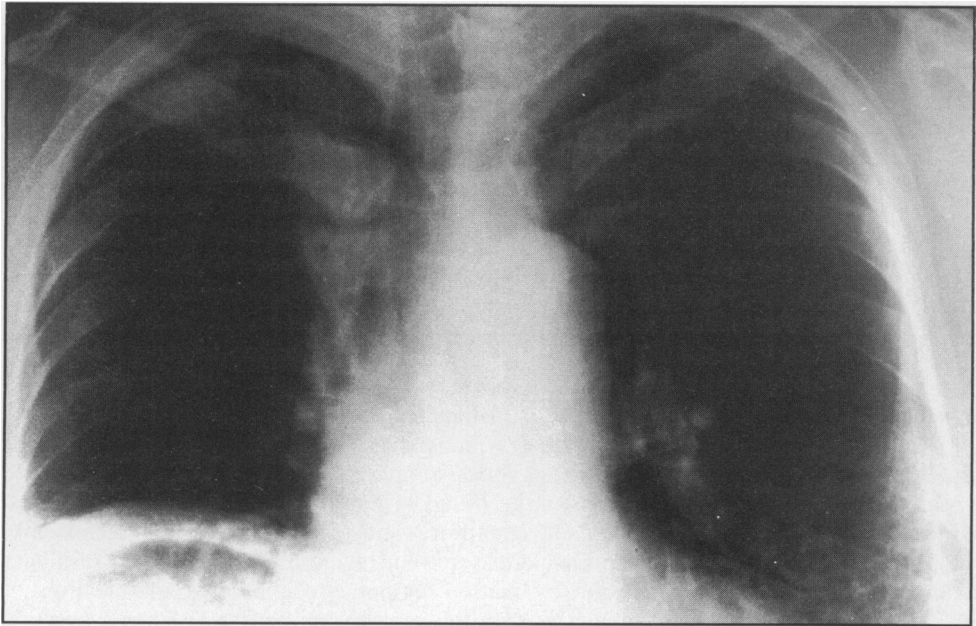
Chest X-ray showing hepatic abscess as gas-fluid level under right hemidiaphragm.
